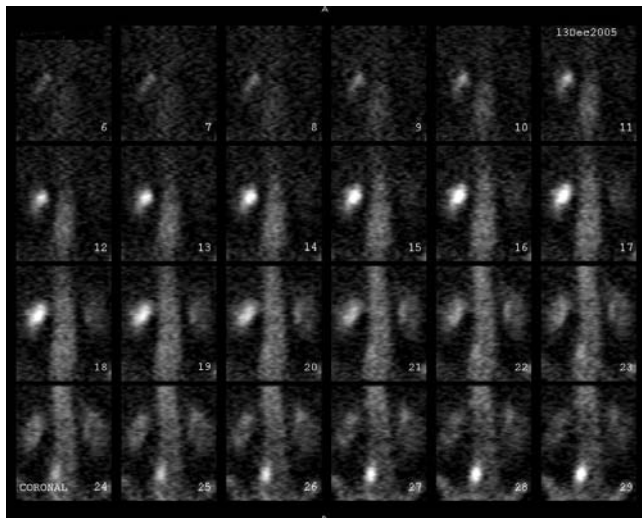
A coronal SPECT sequence shows increased uptake at the right L4-5 facet (images 22-29).
